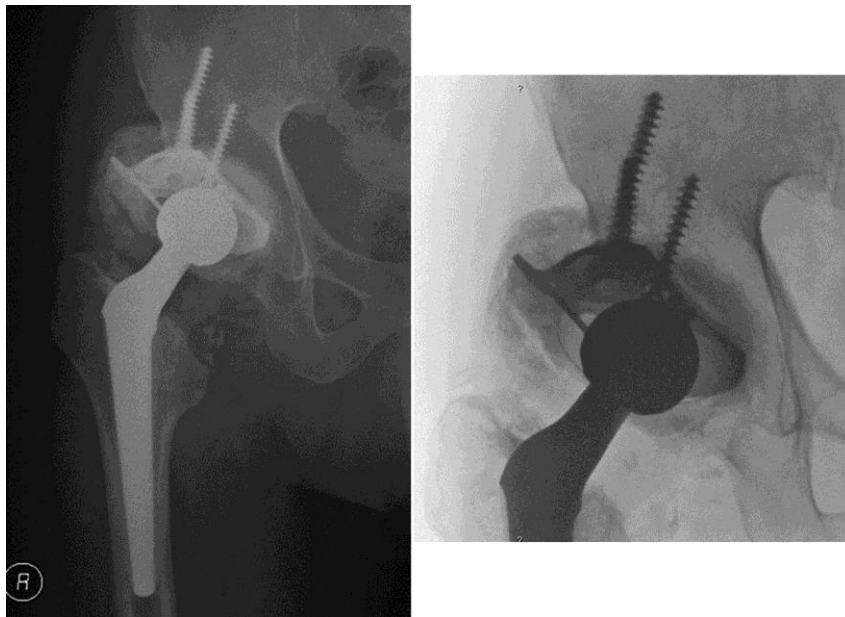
At follow-up period of 4-years, the THA radiograph showed stability of both components and no signs of bone graft resorption. Heterotopic ossifications with no functional impairment. The patient reported no pain and expressed high satisfaction with the surgery result.
